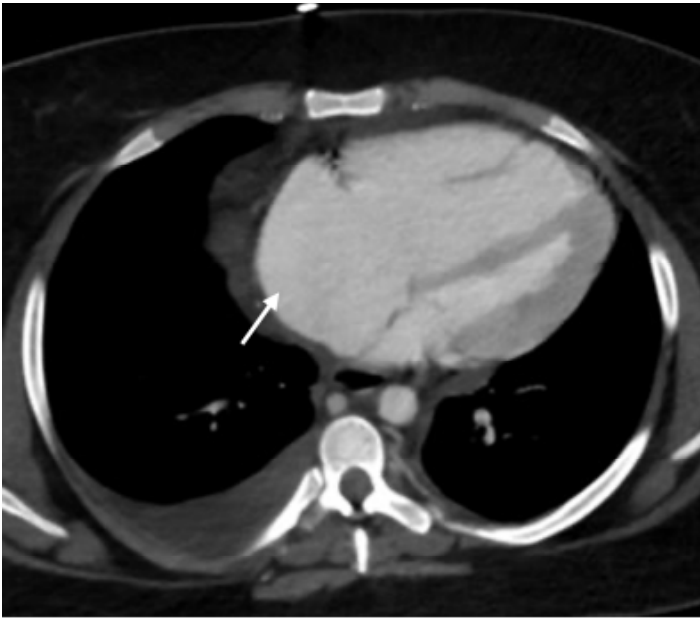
Enlargement of the right ventricle and right atrium (white arrow) seen on computed tomography.
